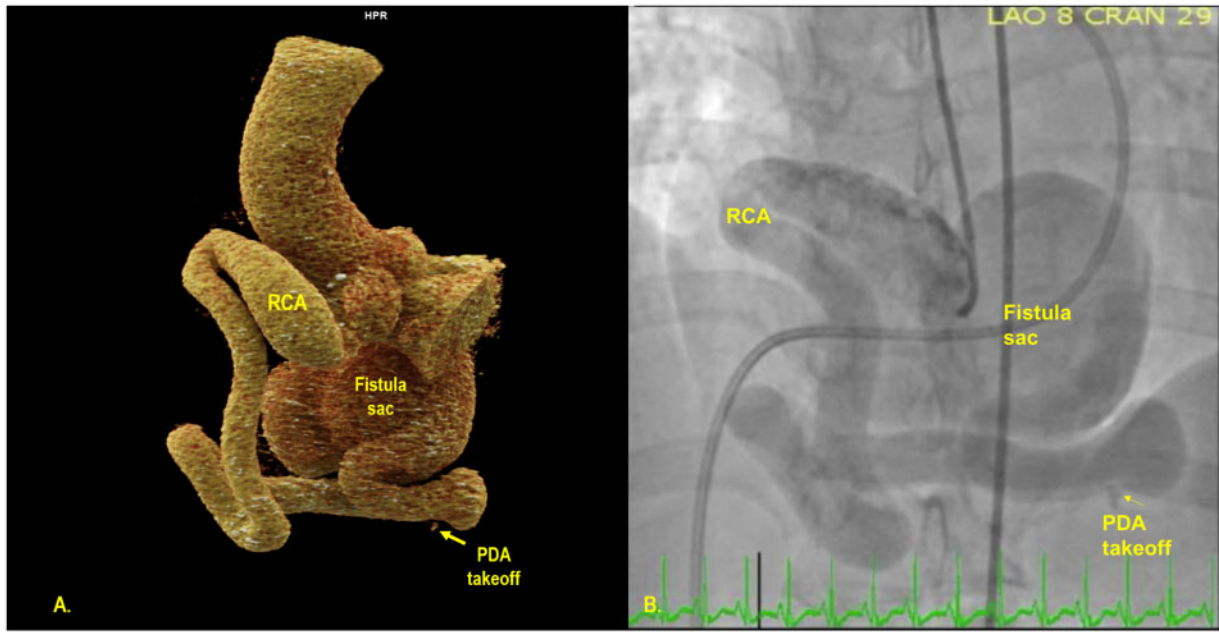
Three-dimensional cinematic rendering of computed tomography angiography (A) and angiography (B) demonstrated a tortuous, ectatic right coronary artery (RCA) with takeoff of the posterior descending artery (PDA) prior to connecting to a large fistula sac.
